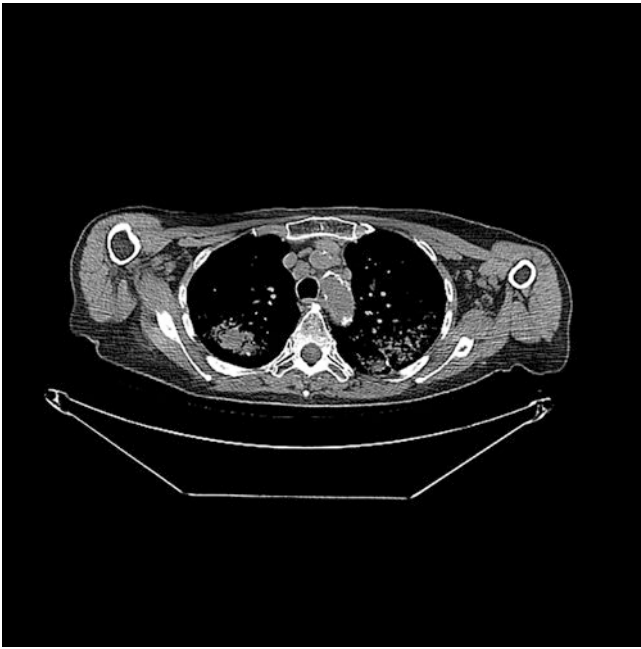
Chest computed tomography scan of a patient with Erdheim-Chester disease shows bilateral consolidative opacities involving the lungs
